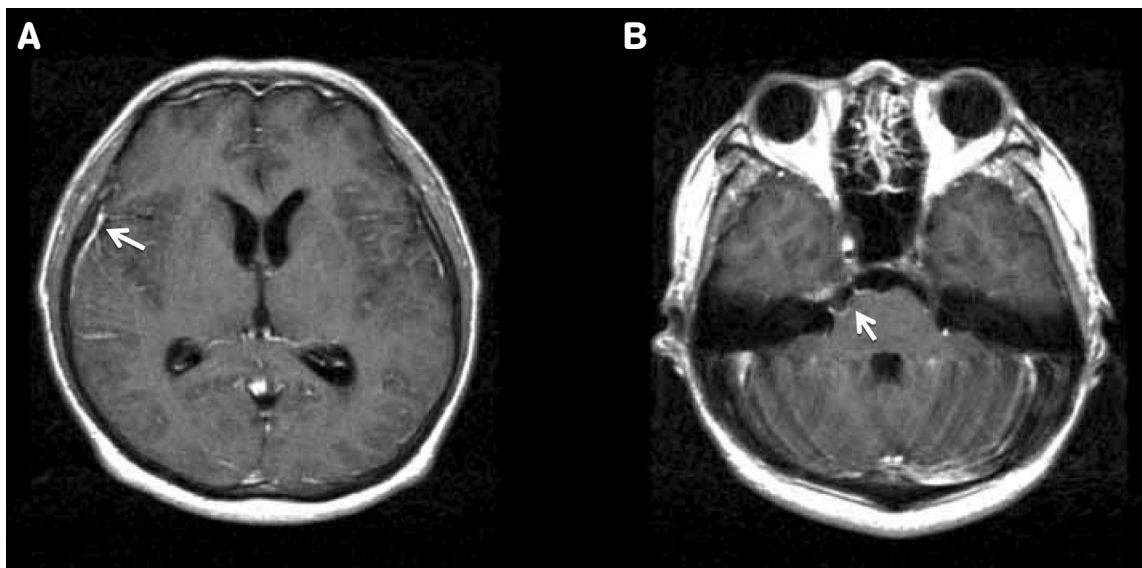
(A, B) T1-weighted magnetic resonance images of the brain after administration of gadolinium contrast show mild leptomeningeal enhancement (arrow).
